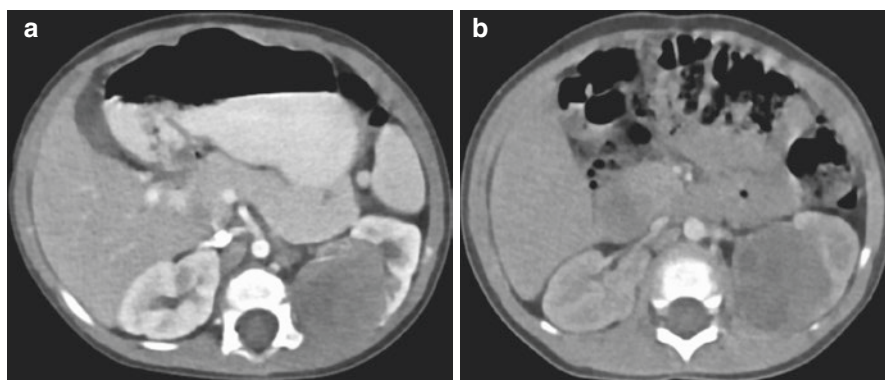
Wilms tumor in a 2-year-old male with WAGR syndrome. (a) Axial CT scan prior to chemotherapy. (b) CT scan following chemotherapy with no significant change in tumor size
